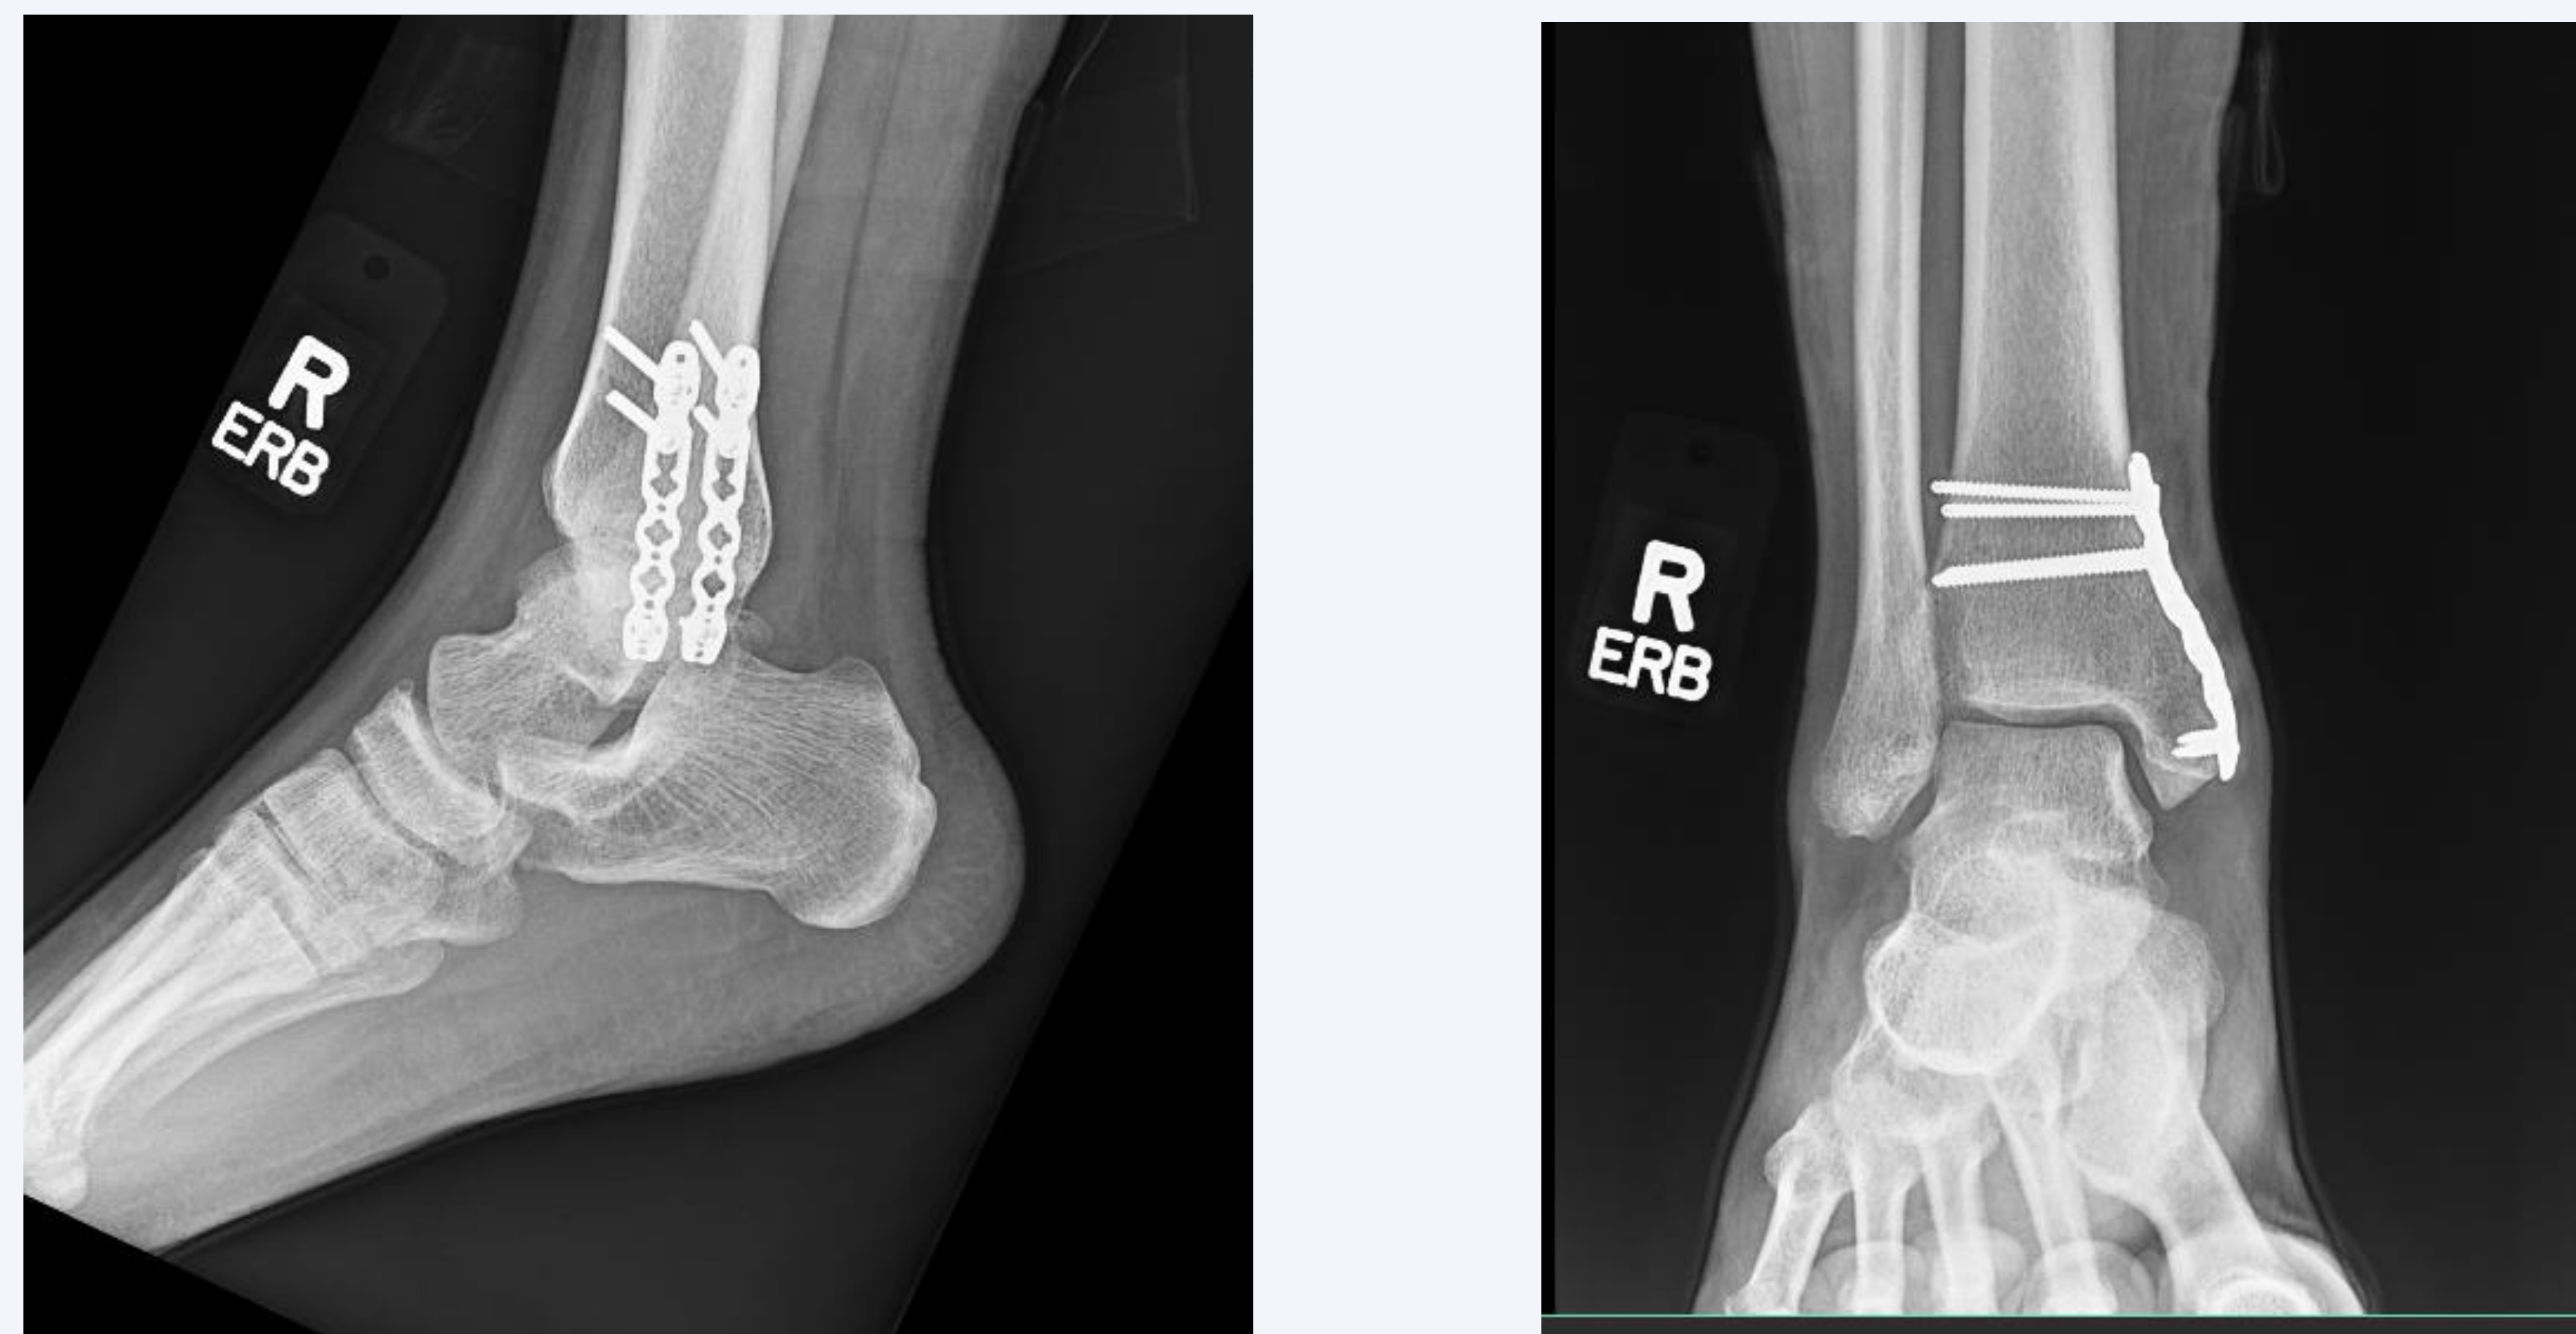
Final post-operative radiographs demonstrating healed medial malleolar fracture with the use of dual plate fixation without evidence of hardware failure or joint arthrosis
